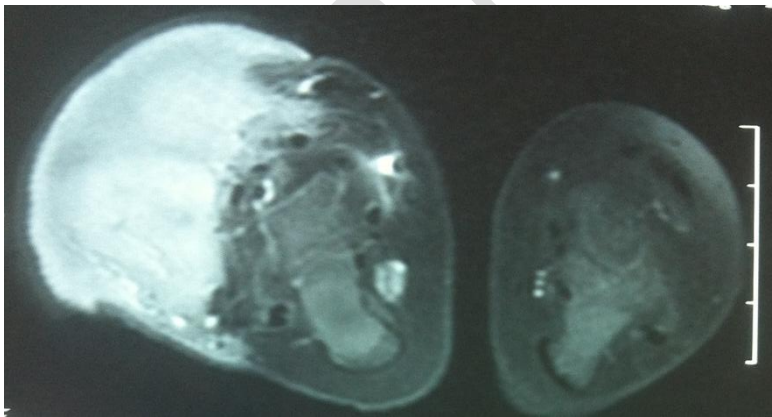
MRI aspect of the mass which sends partitions in under aponeurotic
